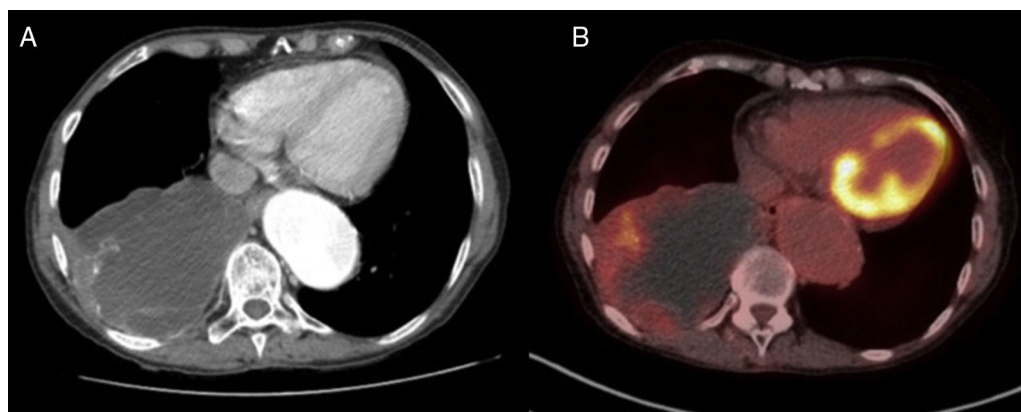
Computed tomography (CT) showing a 10.6 cm mass in the right lower lobe with calcified walls, compatible with a bronchogenic cyst (A). PET-CT showing an ametabolic mass with mild increased uptake in the peripheral area (B).
